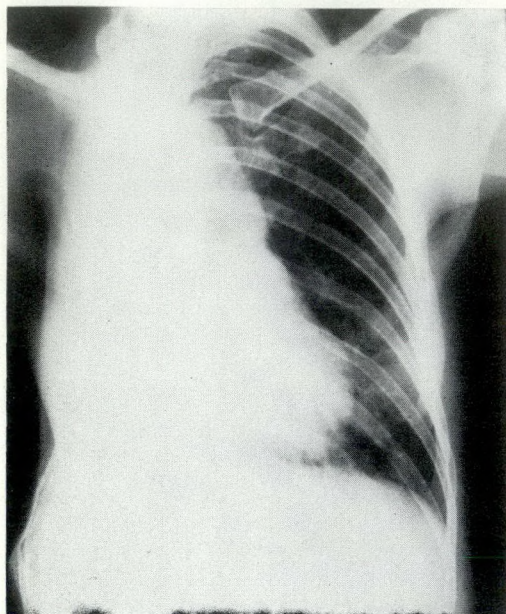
L.B. Chest radiograph November 17, 1961. A post-pneumonectomy empyema was cured by a right, ten-rib thoracoplasty and parietal pleurectomy. The patient is now in good health.
